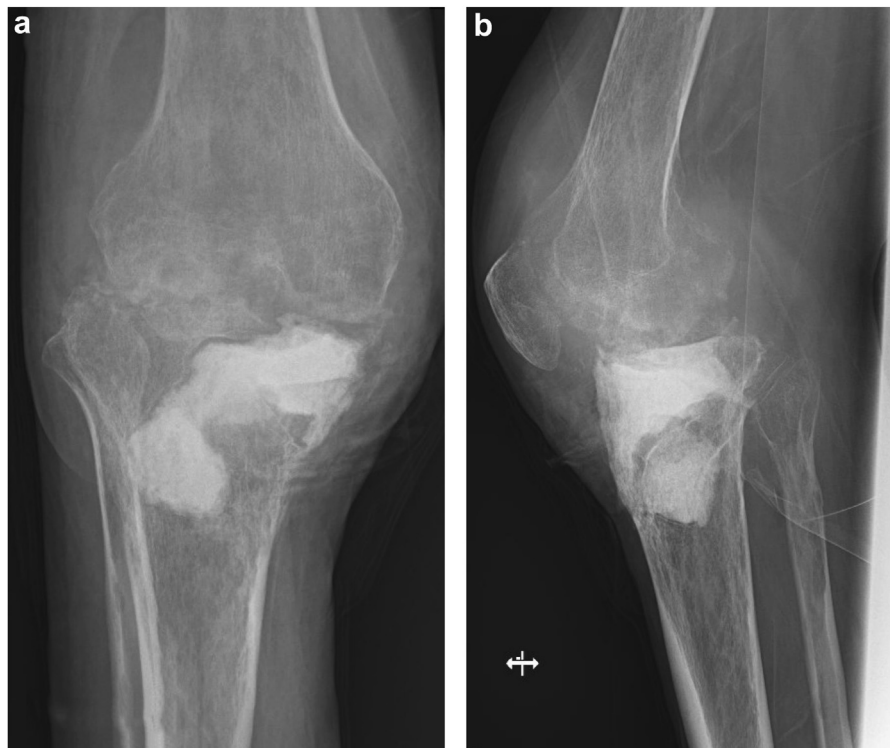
Preoperative (a) anterior-posterior and (b) lateral view radiographs demonstrate radiolucency of cement augment.
